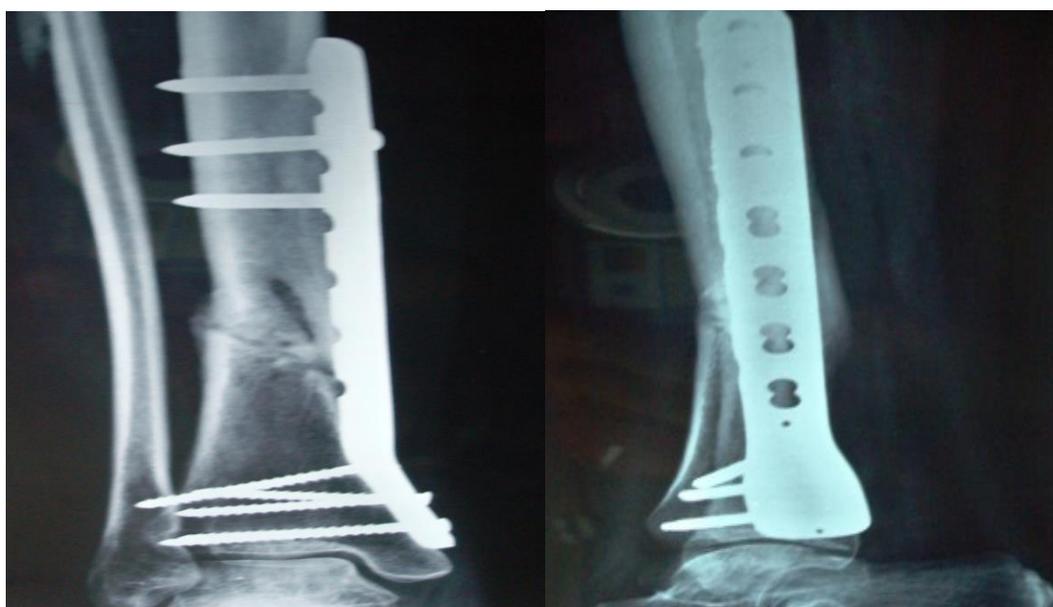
Three month follow-up Anteroposterior and lateral Xrays showing callus formation
